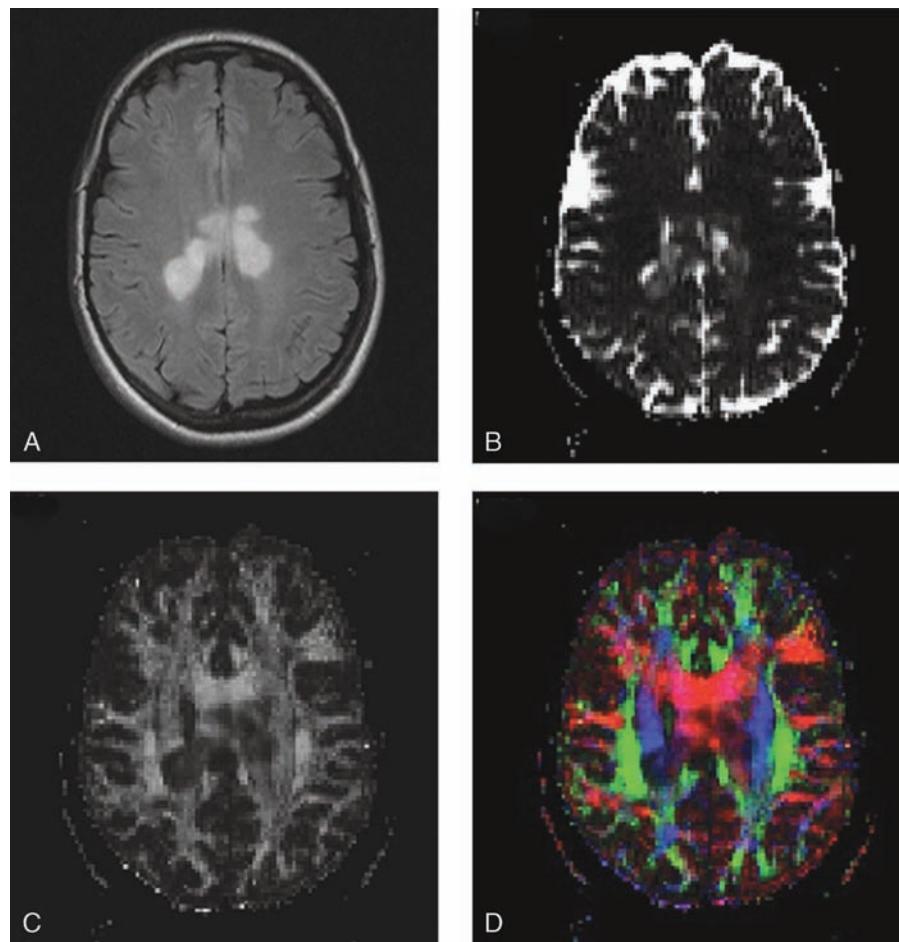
Multiple sclerosis. (A) FLAIR image, (B) ADC map, (C) FA map, and (D) DTI-based color map from the brain of a patient with MS. The lesions demonstrate increased ADC value and reduced FA value. Abbreviations: FLAIR, Axial fluid-attenuated inversion recovery; FA, fractional anisotropy; ADC, apparent diffusion coefficient; MS, multiple sclerosis.
